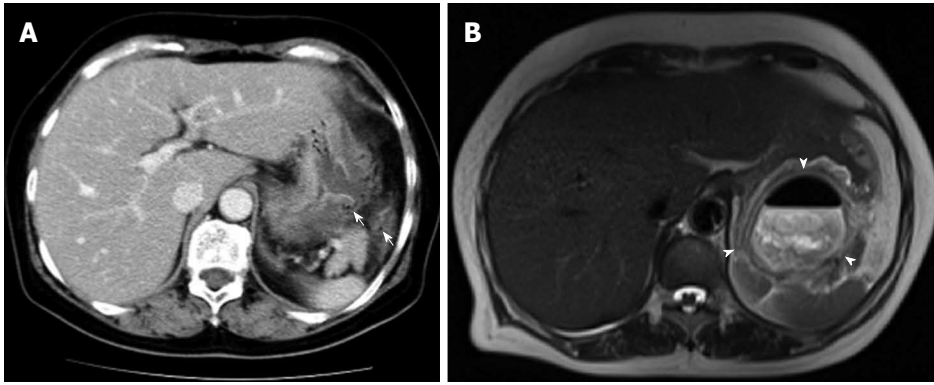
Abdominal computed tomography and magnetic resonance imaging findings. A: Abdominal computed tomography (CT) revealed a portion of the thickened gastric wall and a small amount of ascites and free air around the stomach. Free air is indicated by the arrow; B: Abdominal T2-weighted magnetic resonance imaging showed a moderately high-intensity tumor with niveau formation, 5 cm in size, located in the posterior wall of the fundus of the stomach, which suggested focal abscess formation. The abscess is indicated by the arrowhead.
